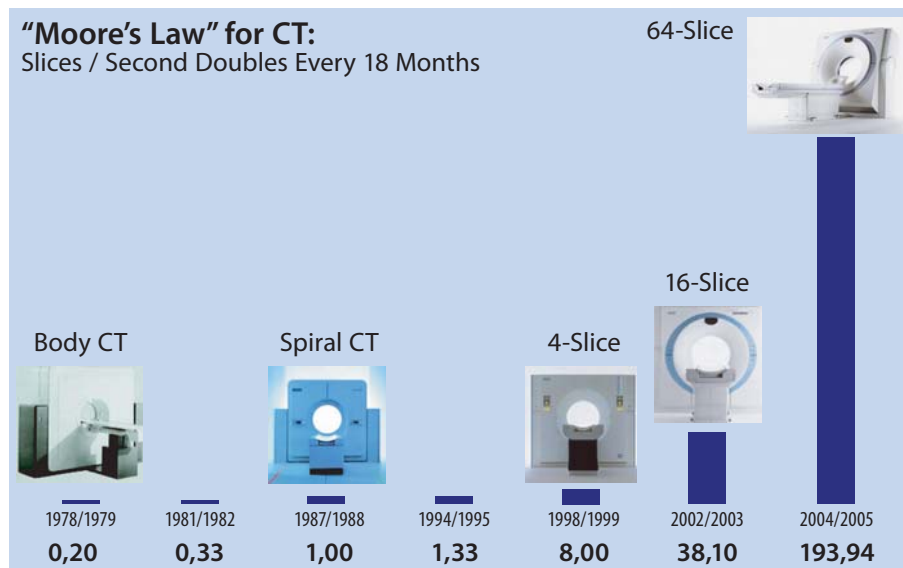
The increased performance of CT since the introduction of multi-slice CT technology in 1998. CT acquisition performance, measured in slices per second, has doubled almost every 18 months and has currently reached nearly 200 slices per second with the latest 64-slice CT scanners
